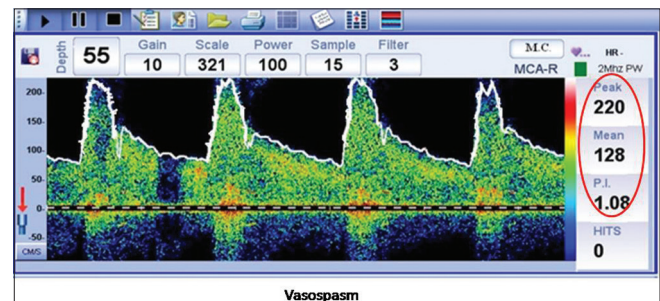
The transcranial Doppler waveform showing vasospasm of the middle cerebral artery. Note the encircled values
